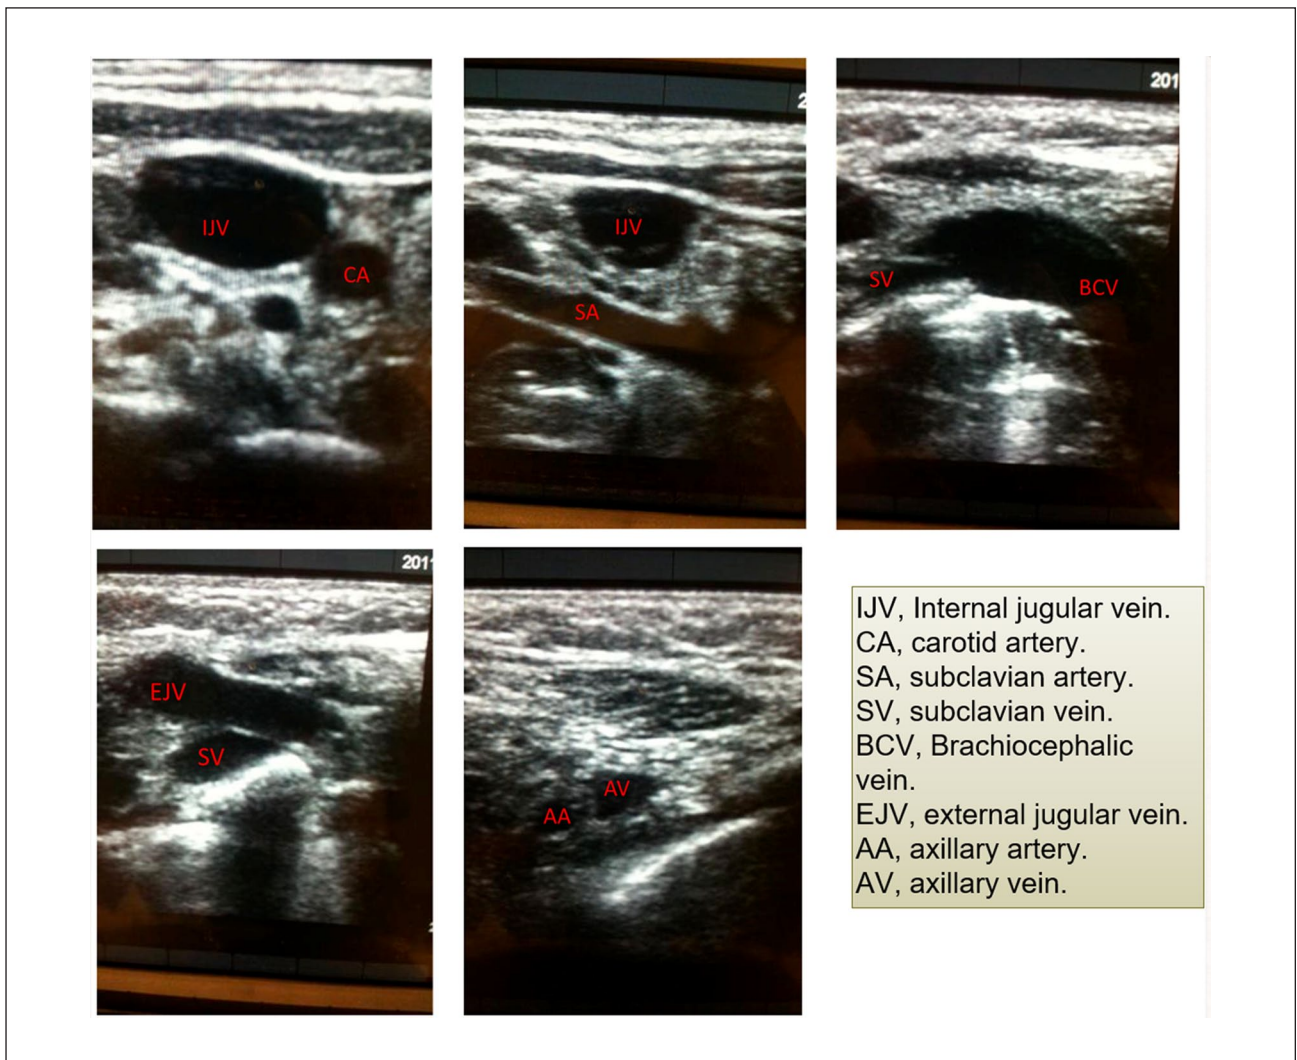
Pre-operative ultrasound scan of central veins (RaCeVA: rapid central vein assessment).
